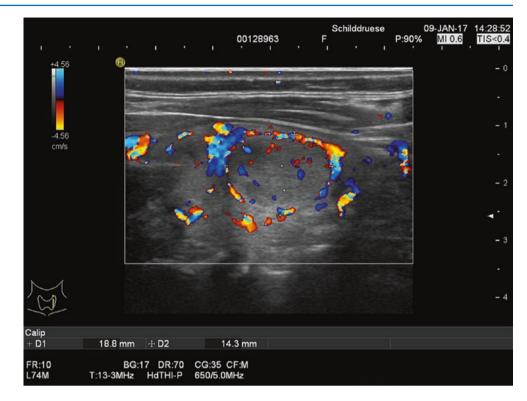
Isoechoic nodule of the right thyroid lobe with "halo effect." It also is taller than wide (a suspicious ultrasound characteristic)
